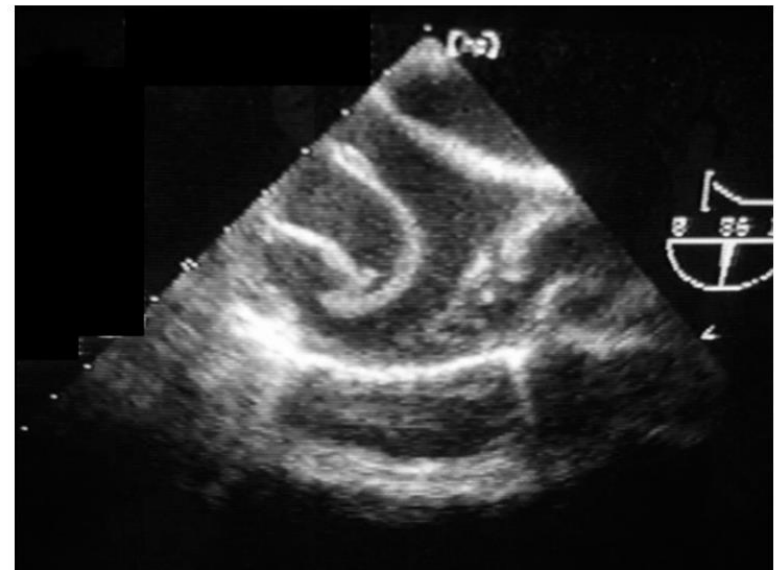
Second transesophageal echocardiography performed on the patient after abrupt onset of chest pain and fever, showing the cyst wall without the multiple, internal, small, kidney-shaped cystic lesions consistent with spontaneous cyst rupture.
